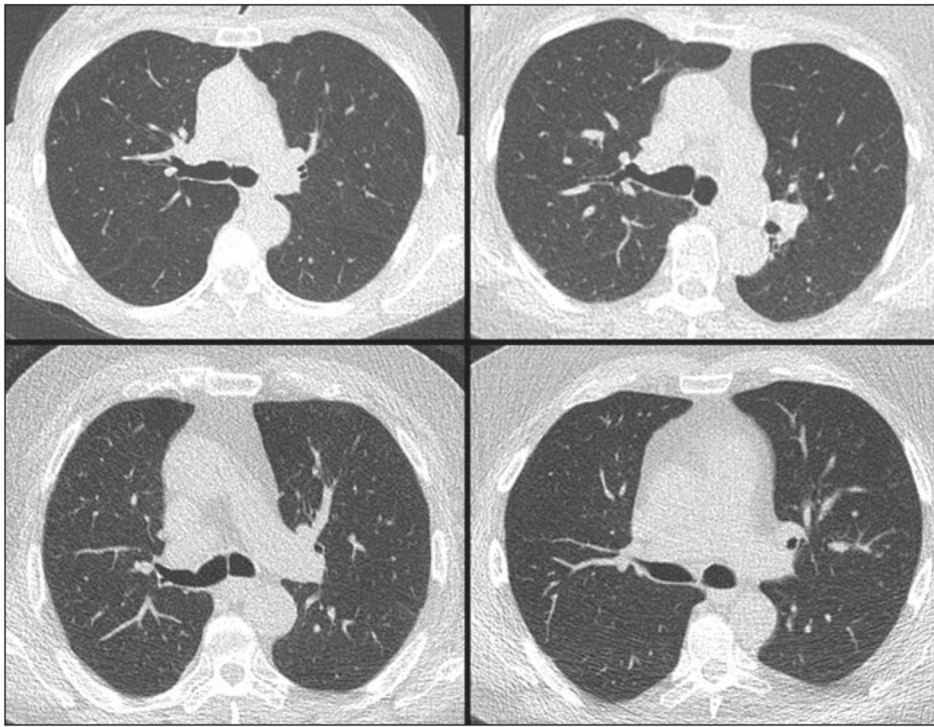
Example images from CT lung cancer screening from Force scanner (Siemens Healthcare) using 100 kV with tin filtration and 150 Quality Reference mAs (Siemens Healthcare). Upper left shows patient with water-equivalent diameter of 28.4 cm (volumetric CT dose index [$CTDI_{vol}$], 0.59 mGy; dose-length product [DLP], 24.2 mGy·cm), upper right shows patient with water-equivalent diameter of 33.1 cm ($CTDI_{vol}$, 1.00 mGy; DLP, 37.7 mGy·cm), lower left shows patient with water-equivalent diameter of 36.4 cm ($CTDI_{vol}$, 1.22 mGy; DLP, 45.0 mGy·cm), and lower right shows patient with water-equivalent diameter of 38.4 cm ($CTDI_{vol}$, 2.1 mGy; DLP, 75.0 mGy·cm).
